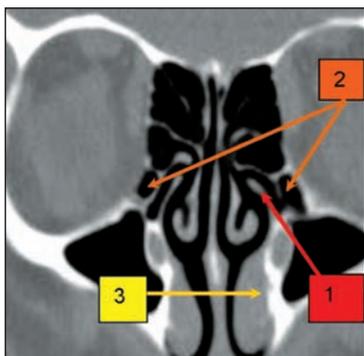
Paranasal sinuses CT scan, bone window, coronal slice: 1. Left uncinatoprocess adherent to a Haller cell, with insertion into the ethmoid bulla; 2. bilateral Haller cell; 3. hypertrophy of the left inferior turbinate
